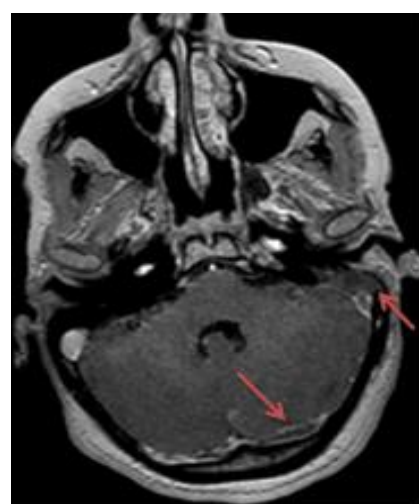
Cerebral MRI in Axial 3D T1 + sequence showing total thrombosis of the transverse and sigmoid sinuses
